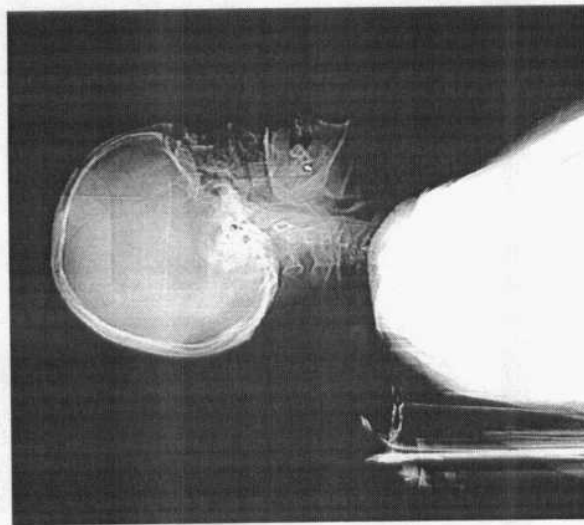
Acquisition of a scout view is the first step in CT angiography
